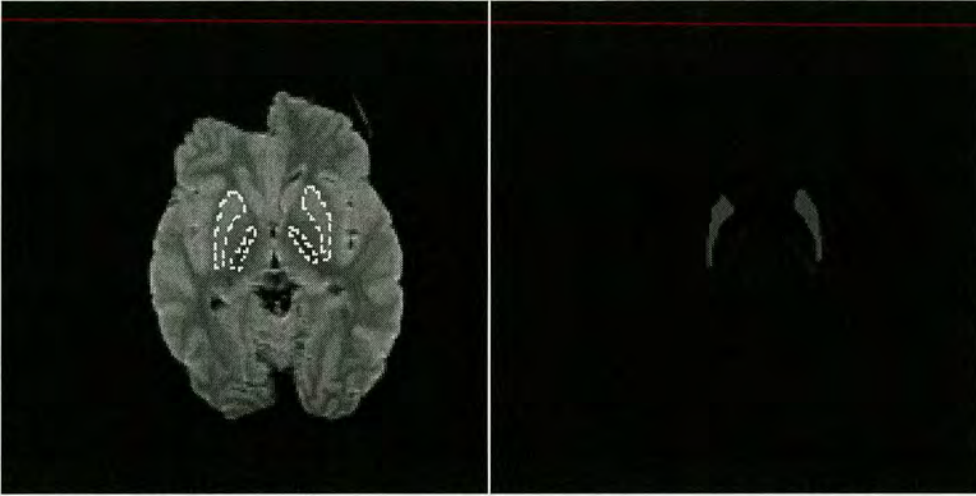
Segmentation: A typical PD weighted MRI (left) and a contrast mask image (right) indicating the Putamen region of the brain (outer segments) and a portion of the Internal Capsule (inner segments) which is selected here to act as a region of contrasting intensity to the Putamen segments.*
